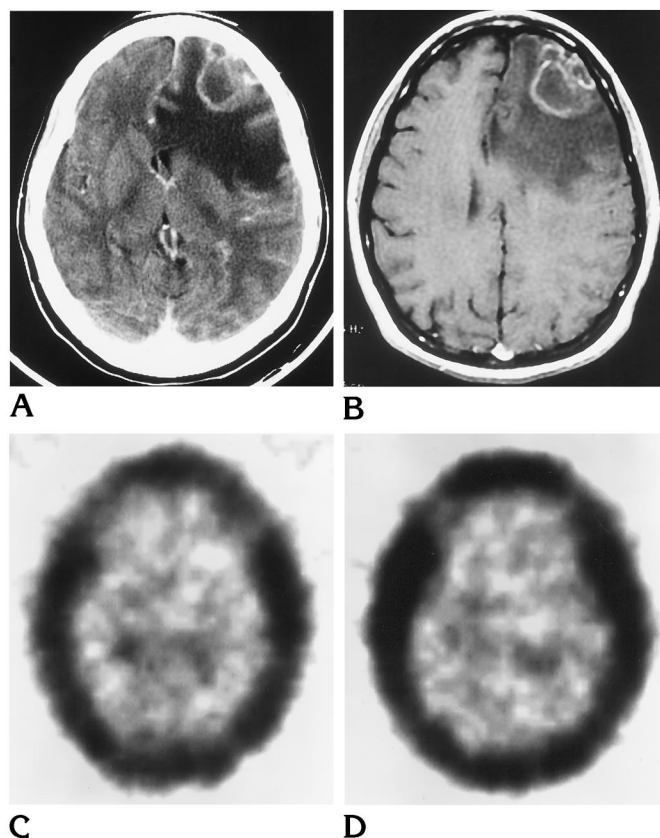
A, Postcontrast CT shows a rim-enhancing left frontal mass with extensive left hemispheric vasogenic edema at the time of admission.
